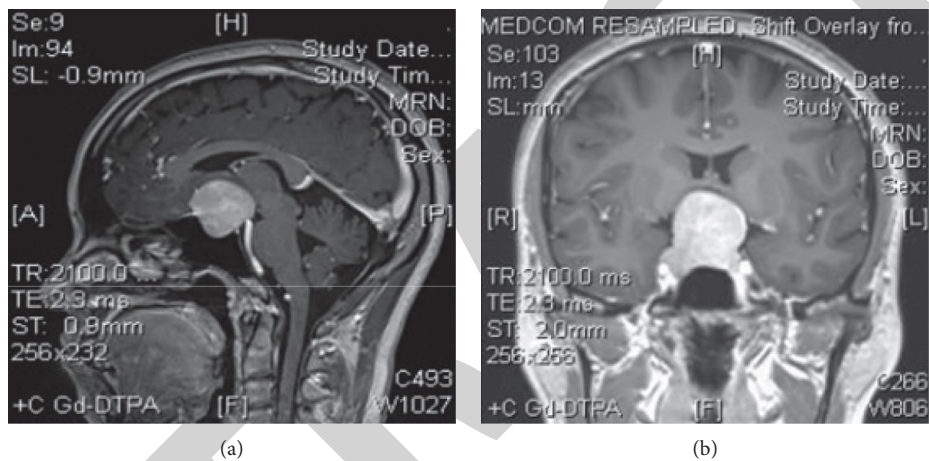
Preoperative MRI of the pituitary gland in the sagittal and coronal positions: (a) preoperative pituitary MRI sagittal position and (b) preoperative MRI coronal position of the pituitary gland.
